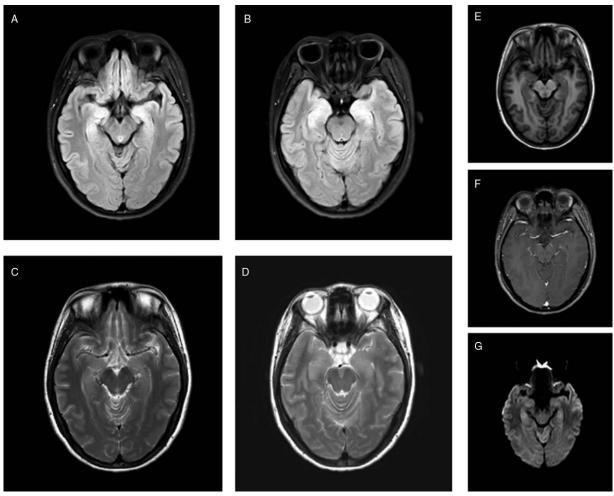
MRI revealed high signals in the bilateral hippocampus regions on flair imaging (A and B); T2-weighted imaging (C and D) showed suspected swelling changes in the bilateral hippocampus; T1-weighted (E), enhanced MRI with gadodiamide (F), diffusion-weighted imaging (G) showed no visual signal or morphological changes in the same region.
